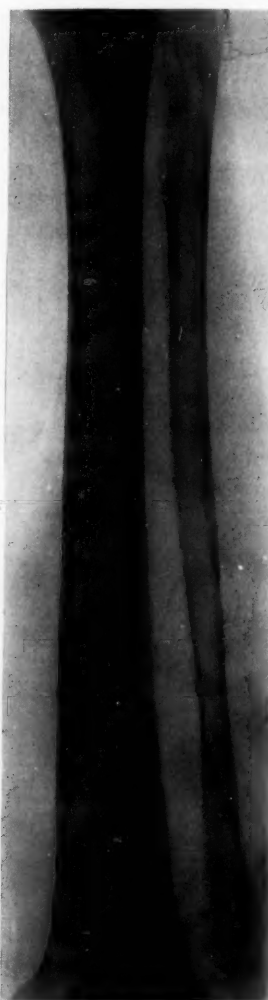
Case I. X-ray showing lesions in upper and lower ends of left fibula.
